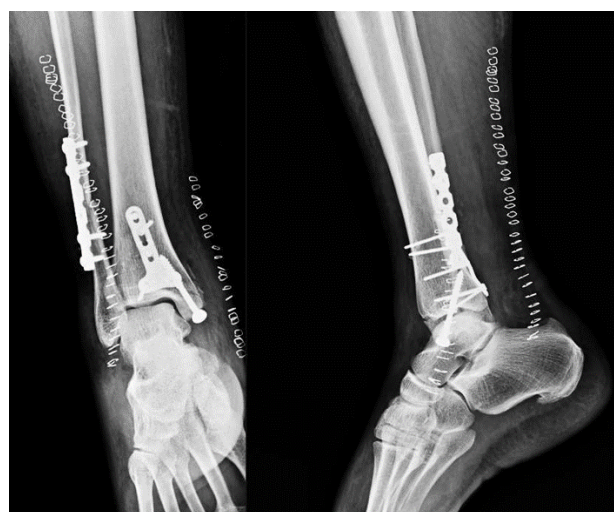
Immediate post op x-ray showing fixation of posterior medial fragment by buttress plate and medial malleolus fixation by one screw and fracture fibula fixation by reconstruction plate.
